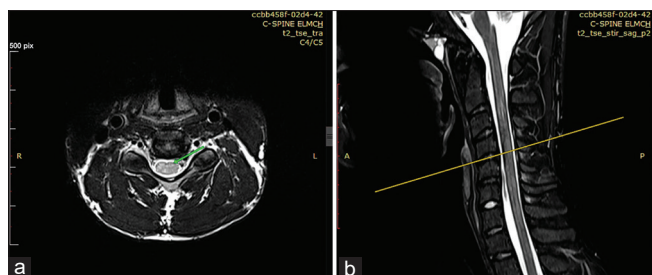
Contrast MRI scans : (a) Axial Section at Cervical Level shows zones of hyper intense signal corresponding to the same level as in sagittal section (b)
